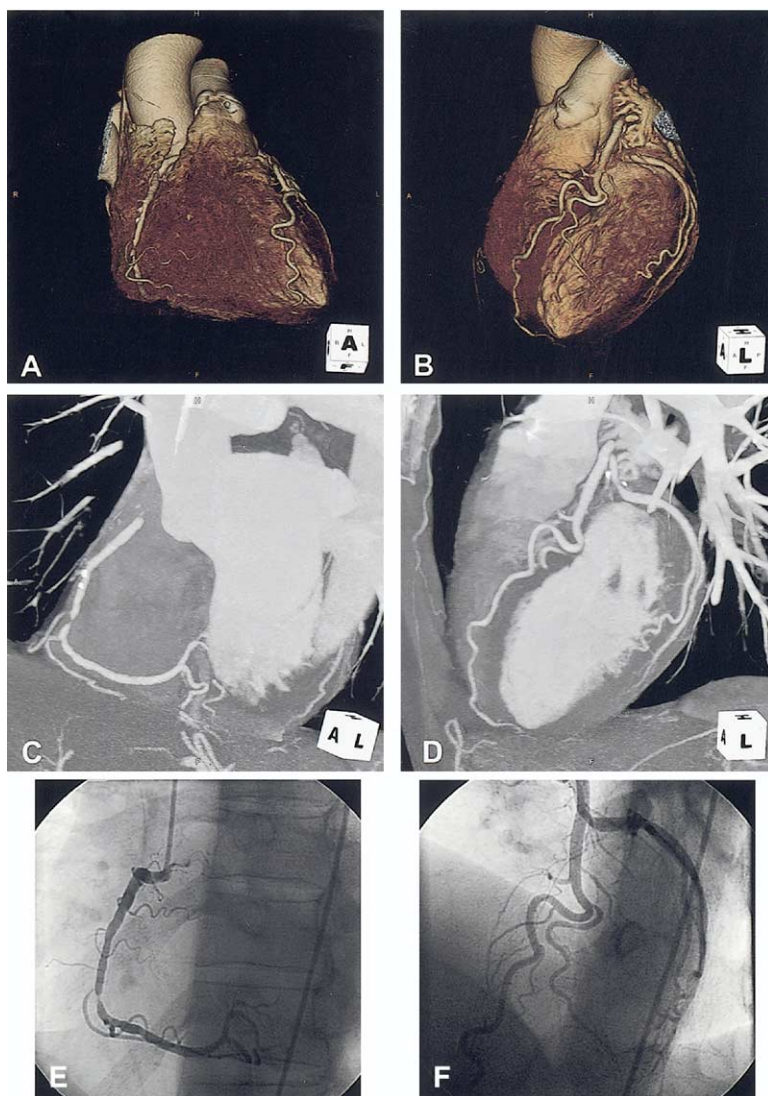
Visualization of soft and hard coronary atherosclerotic plaques by 64-slice multislice computed tomography (MSCT). (A, B) Volume rendering technique demonstrates stenosis of right coronary artery below the acute marginal branch (A), as well as nodular coronary calcifications largely extrinsic to the right coronary lumen and (B) normal left coronary artery. (C, D) Maximum-intensity projection of the same arteries demonstrates severe soft plaque stenosis of the right coronary artery and superficial calcific plaque. (E, F) Invasive coronary angiography of the same arteries.
